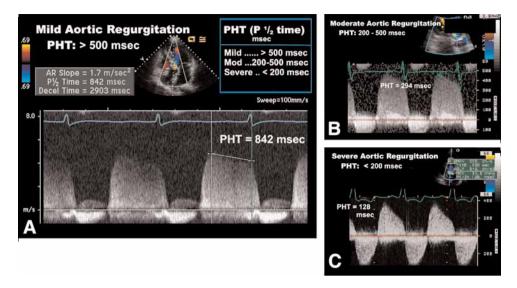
Deceleration rate. The rate of deceleration of the continuous-wave Doppler signal reflects both the degree of regurgitation and the ventricular end-diastolic pressure.
